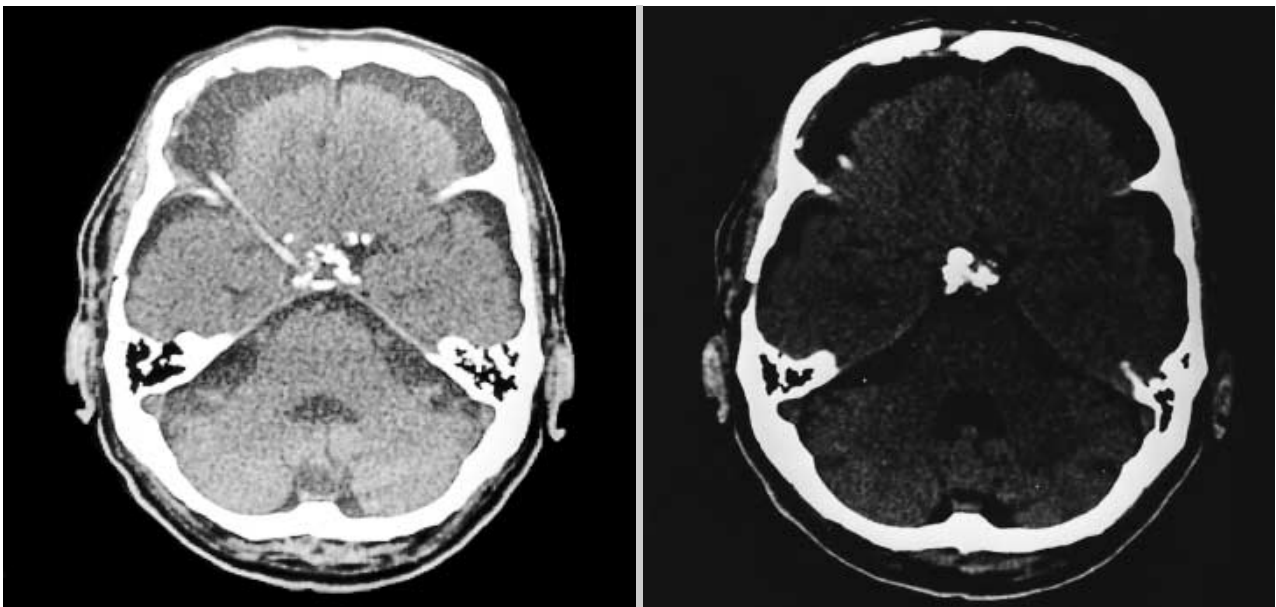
Brain CT of Patient No. 6 six months after a partial tumor removal and intracavitary bleomycin injection.
